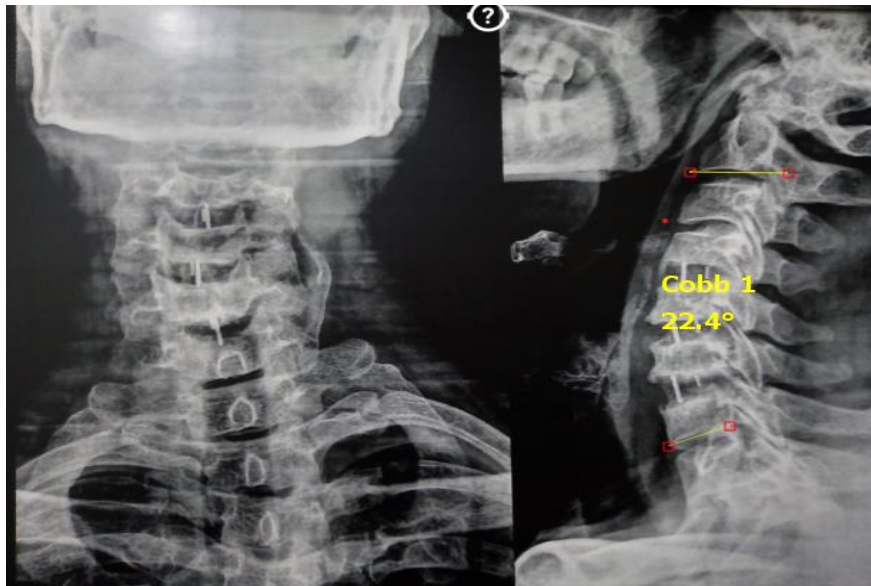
Postoperative X-ray AP and lateral view at 3 months Cobb angle 22.4°.
